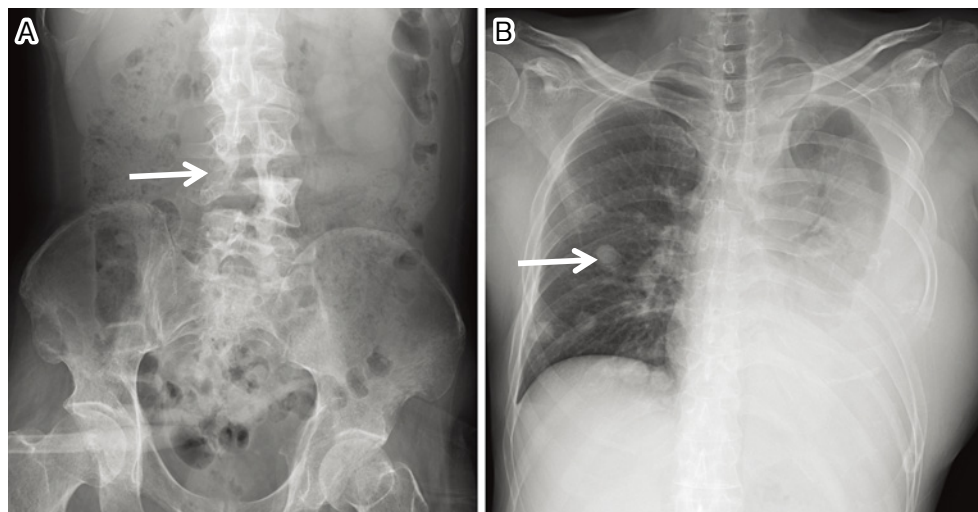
X-ray of the chest and spine showing (A) expansion of scalloping and (B) multiple metastasis within the lung.
